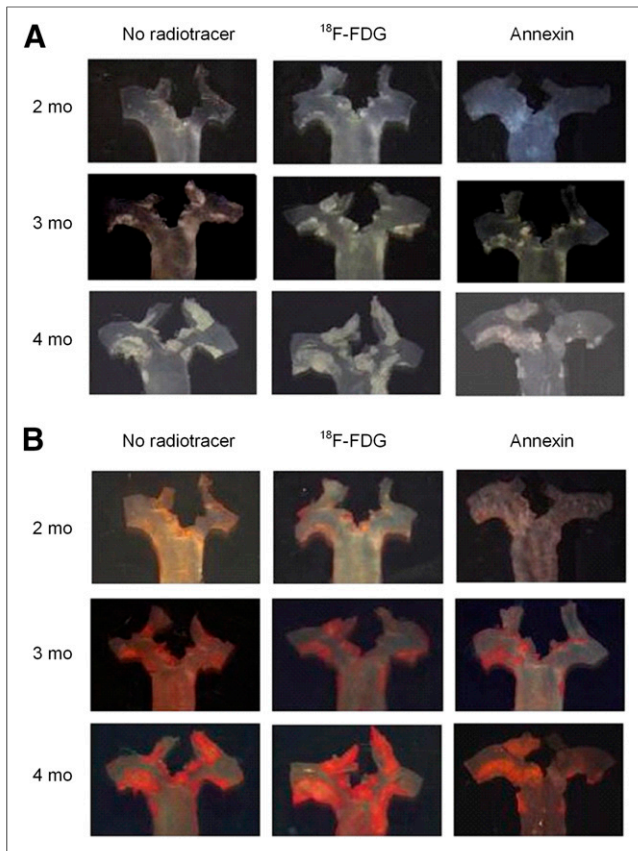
Extent of aortic atherosclerosis shown by en face (A) and Oil red O images (B). Extent increased over time (2, 3, and 4 mo) but did not differ with treatment (no radiotracer, ¹⁸F-FDG, and ^{99m}Tc-rhAnnexin V-128).
